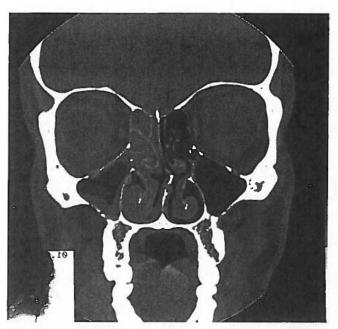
Coronal CT-scan of the paranasal sinuses showing unilateral ethmoidal and maxillary sinuses disease as a causative factor.
